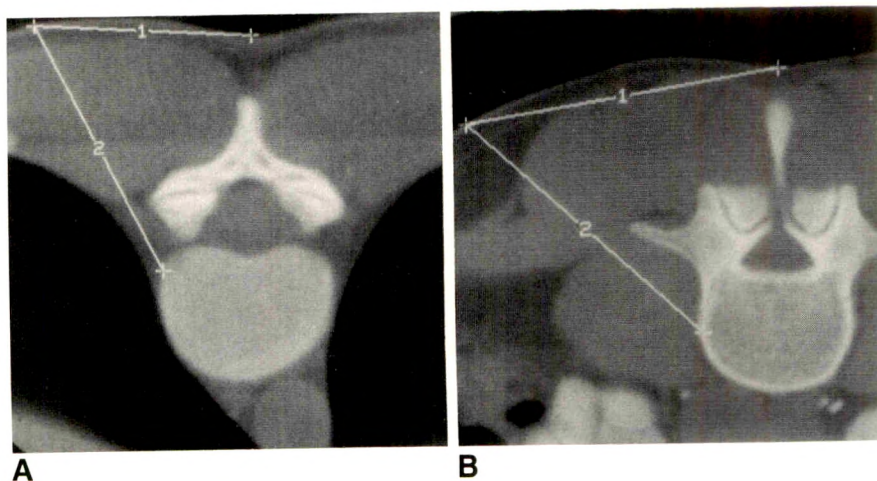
A, CT scan of extrapleural approach to a high thoracic vertebra. Distance from midline is measured and marked on patient's skin. Needle should be angled steeply (in this case approximately 30° from vertical).
